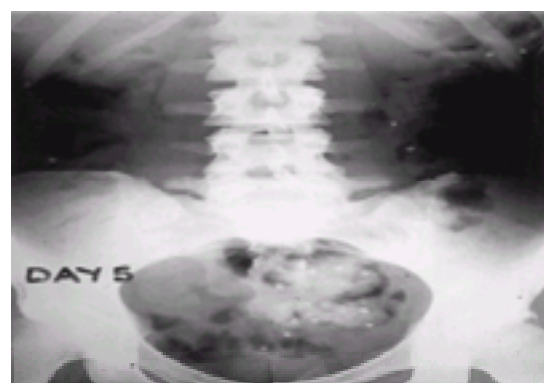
Plain radiograph 5 days after the ingestion of 20 radio-opaque markers. More than 80 per cent are still present, indicating slow transit.
